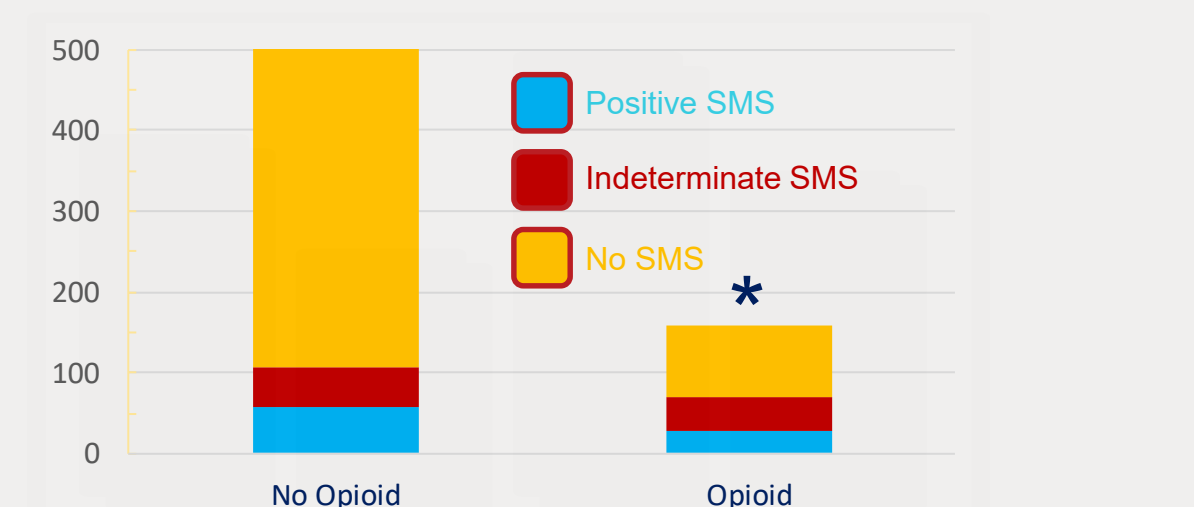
Opioid administration does affect a finding of positive or an indeterminate sonography Murphy sign (p<.0001).
